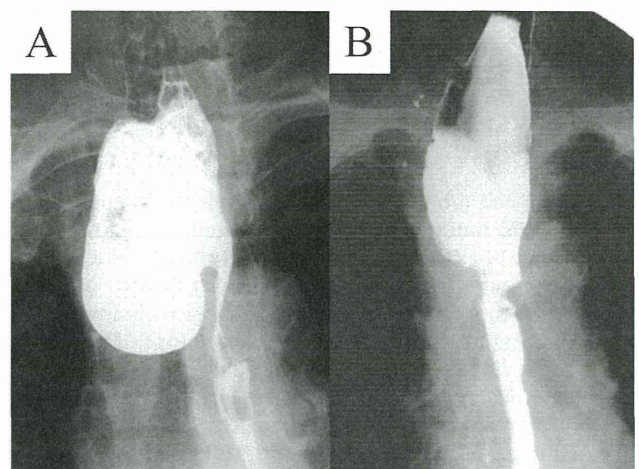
Preoperative and postoperative barium swallow radiographs. (A) Preoperative barium swallow radiograph shows significant retention of barium in a massive Zenker's diverticulum, reaching the carina (10.0 × 6.0 cm), with minimal conduction of barium into the distal esophageal lumen. (B) Postoperative barium swallow radiograph demonstrates free flow of barium into the esophagus and shrinkage of the hypopharyngeal dilatation.
